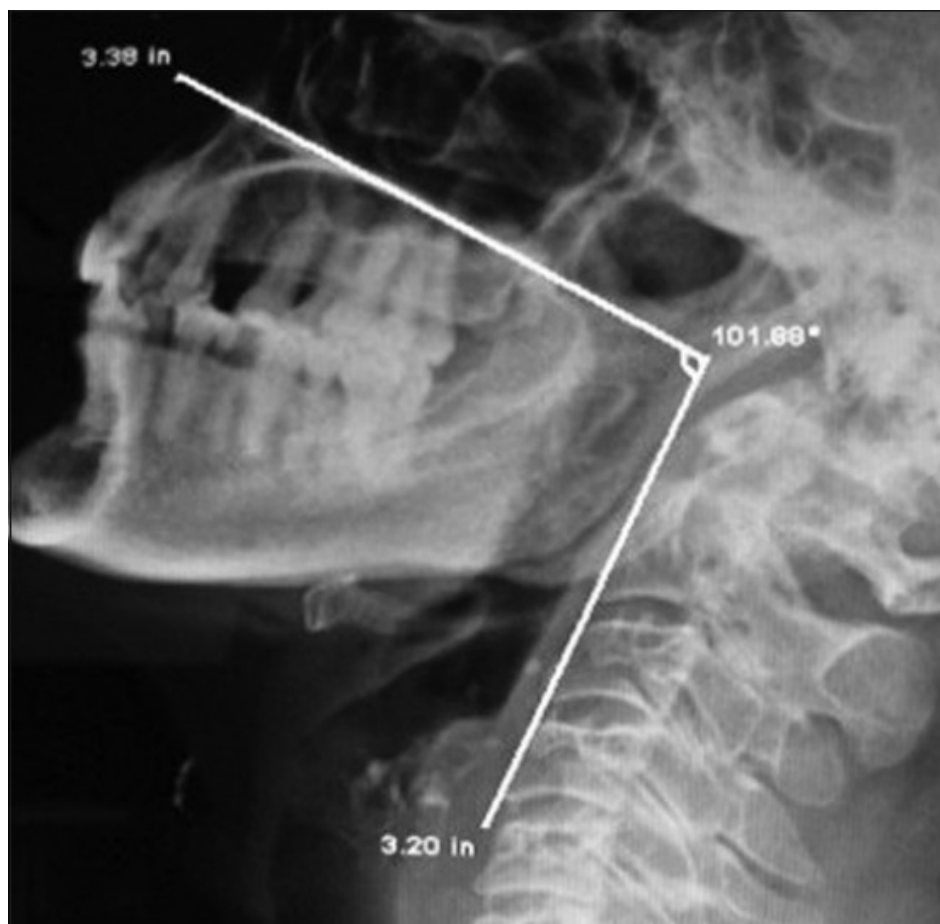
An example of lateral cervical radiograph with measurement of the maxillo-pharyngeal angle formed by the maxillary axis and pharyngeal axis
